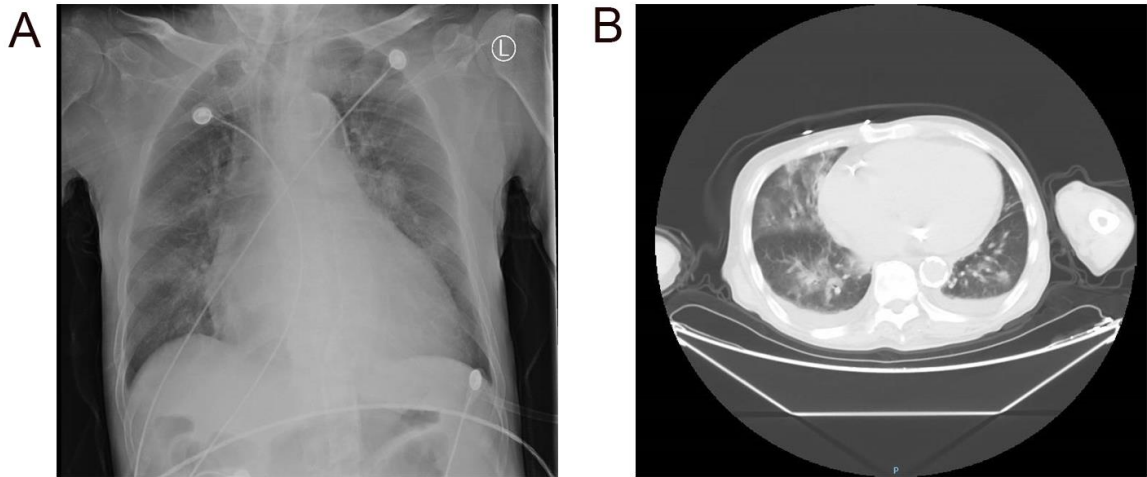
Male, 66 years old, admitted to hospital on January 15th because of "regular dialysis 9 years, chest tightness, wheezing for 1 week"; the patient has 20 years of hypertension; cerebral infarction in 2005; started regular hemodialysis in 2010; Renal tuberculosis was found in the year 2014. 2020-01-17 Chest X-ray: bilateral lung infection, significantly enlarged heart with cardiac insufficiency (pulmonary edema); 2020-01-19 chest CT: bilateral lung infection (viral pneumonia?), Bilateral pleural effusion, enlarged heart shadow, a small amount of pericardial effusion, and widening of the pulmonary artery trunk; aortic and coronary atherosclerosis; mitral valve calcification; double renal nodules, and further examination is recommended. 1-23 Pharyngeal swabs were positive for nucleic acid diagnosis of SARS-CoV-2 pneumonia, transferred to the intensive care unit, and died at 1-24. The cause of death was considered severe pneumonia with cardiac insufficiency and sepsis.
